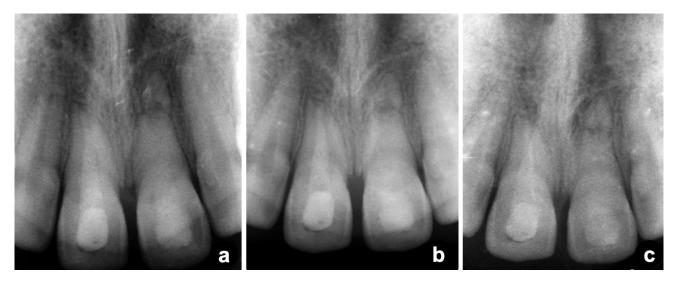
a:3-months follow-up radiograph after endodontic treatment. b:6-months follow-up radiograph. c:12-months follow-up radiograph.
